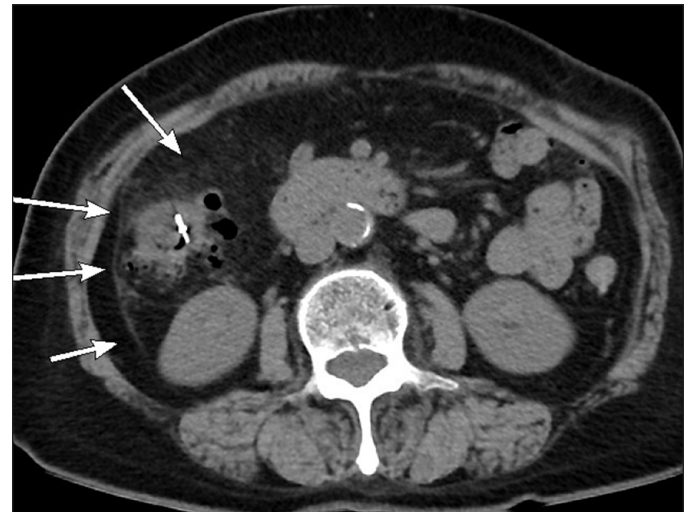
CT revealed dirty fat around the ascending colon and thickened peritoneum without perforation or abscess formation. The marking hemoclip can be observed in the ascending colon.
